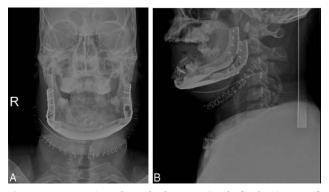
Postoperative radiographs demonstrating the fixed patient-specific implants in proper facial relations. (A) Anterior-posterior cephalometric radiograph. (B) Lateral cephalometric radiograph.
